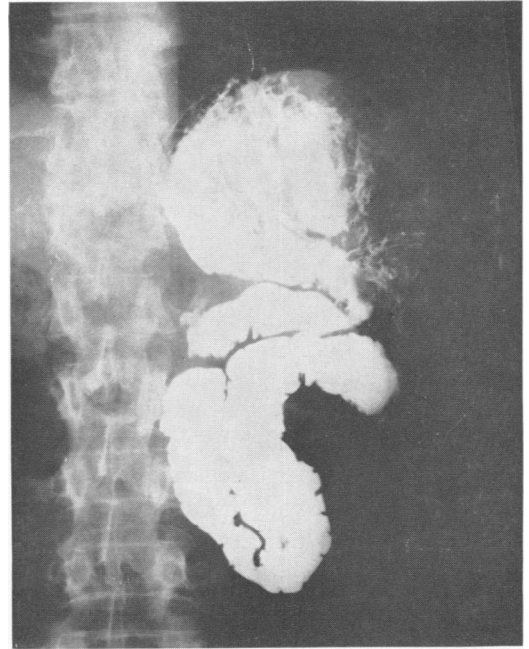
Radiograph demonstrating jejunogastric intussusception in Case 4.
